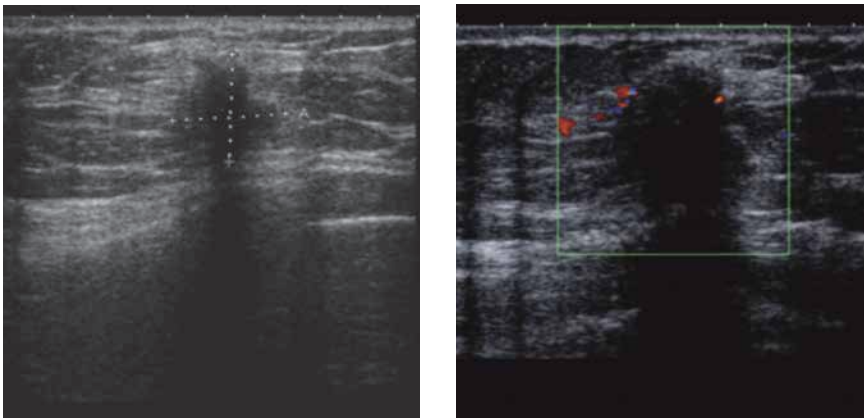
Ultrasound of the right breast shows a hypodense mass with a marked retro-acoustic shadow and irregular borders. Diameters of 14,8 × 14,0 millimeter.
